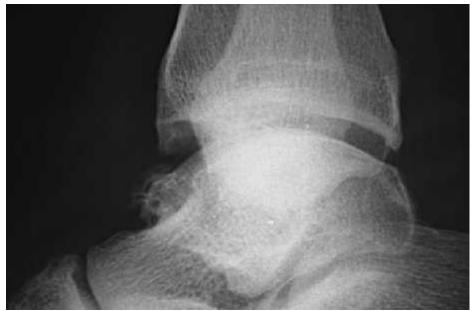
lateral ankle radiograph, anterior tibial and talar osteophytes.
